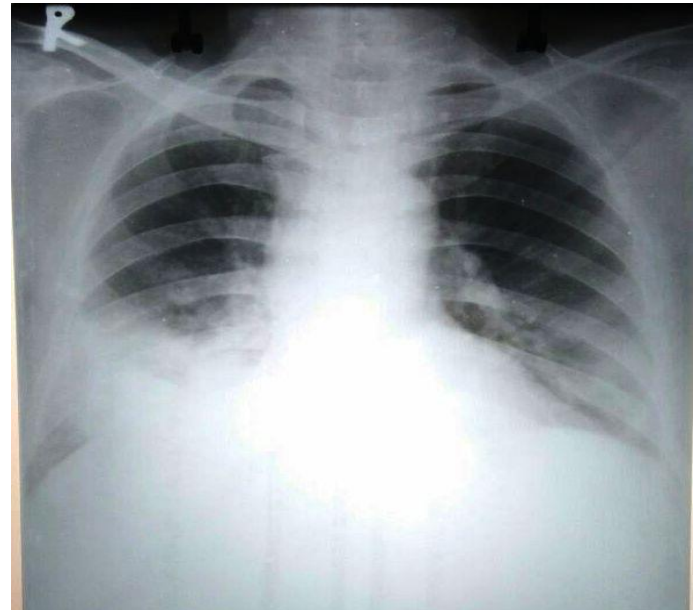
1 Chest Xray Showing Right Lower Lobe Pneumonitis
